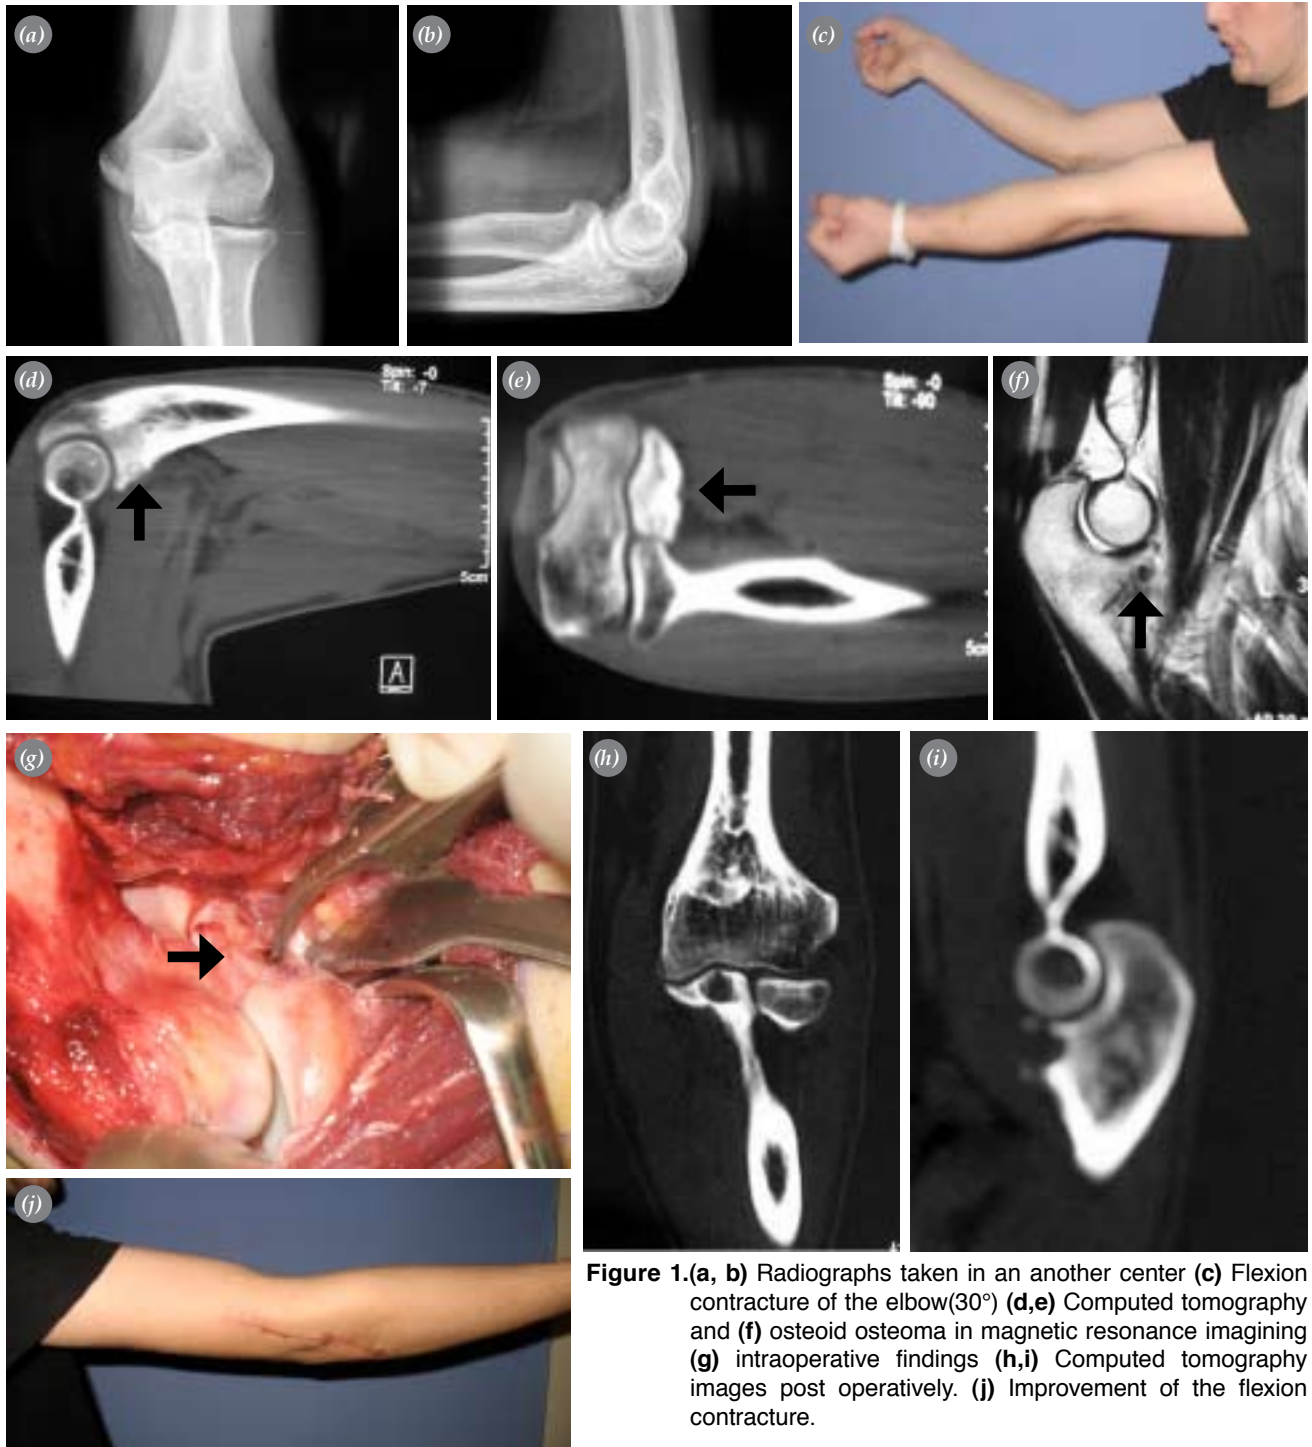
(a, b) Radiographs taken in another center (c) Flexion contracture of the elbow (30°) (d, e) Computed tomography and (f) osteoid osteoma in magnetic resonance imaging (g) intraoperative findings (h, i) Computed tomography images post operatively. (j) Improvement of the flexion contracture.
